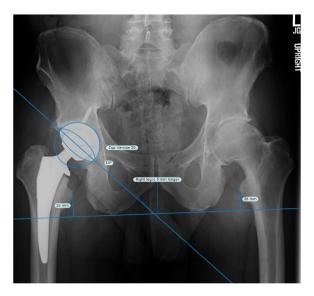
Postoperative AP pelvis radiograph demonstrating use of the elliptical principle and known cup diameter to measure acetabular version. Acetabular inclination is measured as the angle subtended by a horizontal reference (line across the ischial tuberosities) and a line across the rim of the cup.
